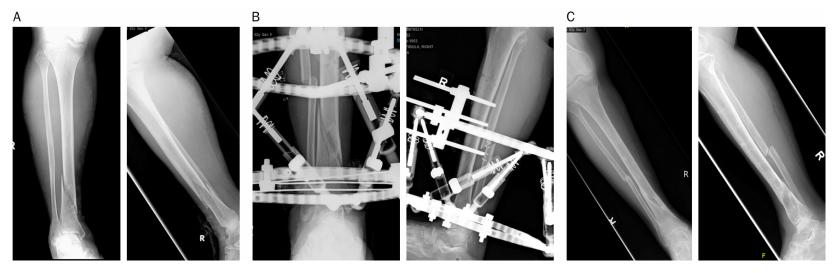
A 62-year-old female involved in a road traffic accident, sustaining a Gustilo 3B distal tibia open fracture. A. Preoperative anteroposterior and lateral radiographs. B. Immediate postoperative anteroposterior and lateral radiograph after multiplanar external fixation. C. 1-year postoperative anteroposterior and lateral radiographs showing bony union and minimal angulation.
